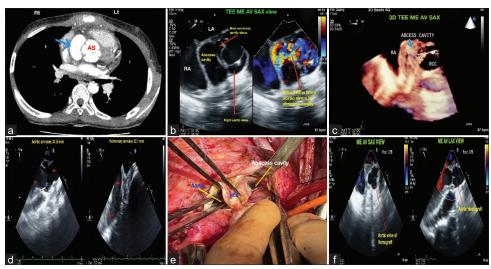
(a) Contrast computed tomography axial section of heart showing a large crescent-shaped contrast enhanced abscess cavity lying adjacent to the aortic sinuses (blue arrow) (b) Pre-CPB TEE ME AV short axis view (color compare) showing large abscess cavity with shunting of blood from non-coronary sinus to abscess cavity during systole (c) Three-dimensional TEE image showing the abscess cavity adjacent to the non-coronary sinus (blue arrow) (d) Pre-CPB TEE showing measurement of size of aortic annulus in ME AV LAX view and size of pulmonary annulus in UE ascending aorta LAX view (e) Surgical image showing the communication between abscess cavity and aortic root (surgical forceps passed from non-coronary aortic sinus to abscess cavity) (f) Post-CPB TEE examination of aortic homograft in ME AV SAX and LAX view. 3D = Three dimensional, AS = Aortic sinus, AV = Aortic valve, CPB = Cardiopulmonary bypass, LA = Left atrium, LAX = Long axis, LCC = Left coronary cusp, ME = Midesophageal, NCC = Non-coronary cusp, NCS = Non-coronary sinus, RA = Right atrium, RCC = Right coronary cusp, SAX = Short axis, TEE = Transesophageal echocardiography, UE = Upper esophageal
